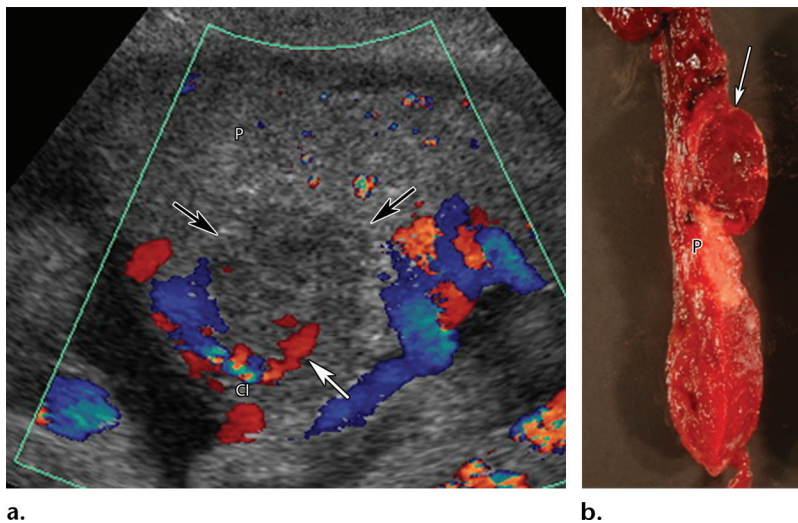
Chorioangioma at 32 weeks gestation. (a) Longitudinal color Doppler image shows a well-circumscribed hypoechoic mass (black arrows) arising from the fetal surface of the placenta (*P*) adjacent to the cord insertion (*CI*). It demonstrates internal vascularity and a large feeding vessel (white arrow). (b) Cut section of the delivered placenta from another patient with chorioangioma. Note the redish mass (arrow) in the placenta (*P*).
